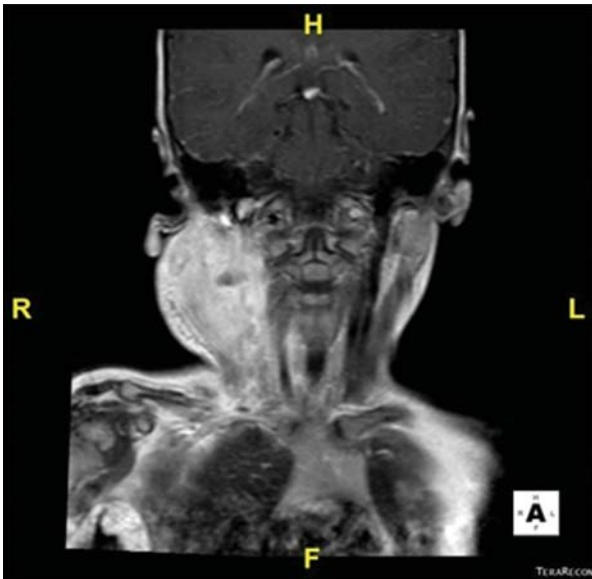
A 4x6 cm conglomerate lymph nodule on the right side of the neck on MRI
